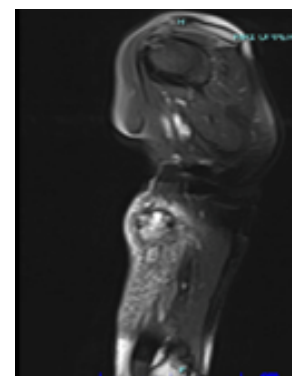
MRI of Left Upper Extremity W/O.
